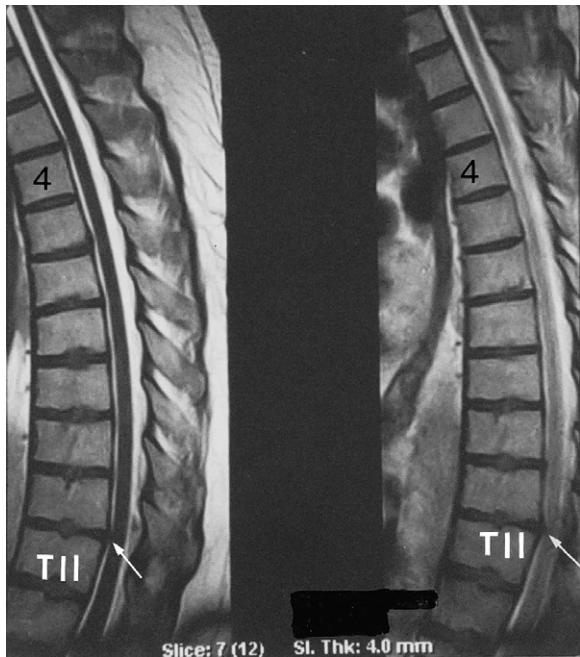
These two T2-weighted sagittal MRI images of the thoracic spine were taken 5 years after the scan shown in Fig. 86.2A. Note that the T10–11 disc protrusion is still present (arrows).
